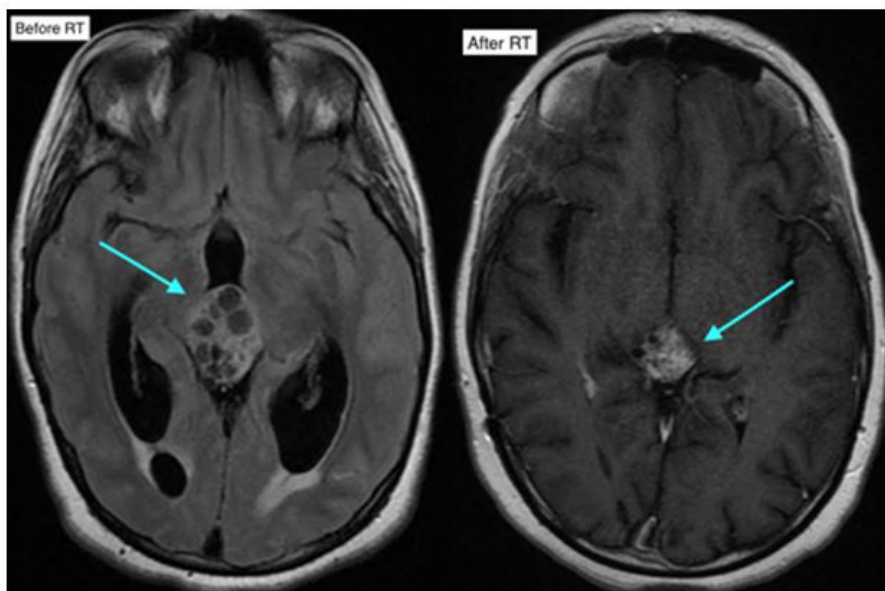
Control MRI after radiation with significant decrease in tumor size
